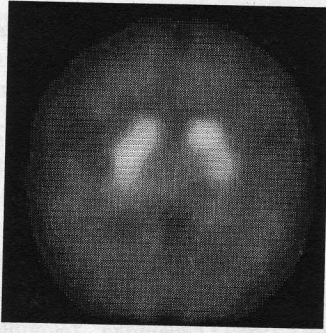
Neuroreceptor SPECT image after anisotropic diffusion process
